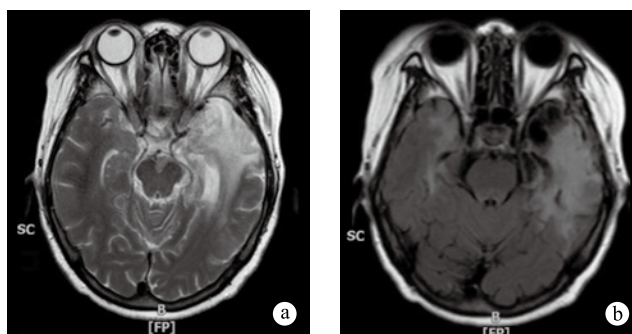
Re-examination of MRI
